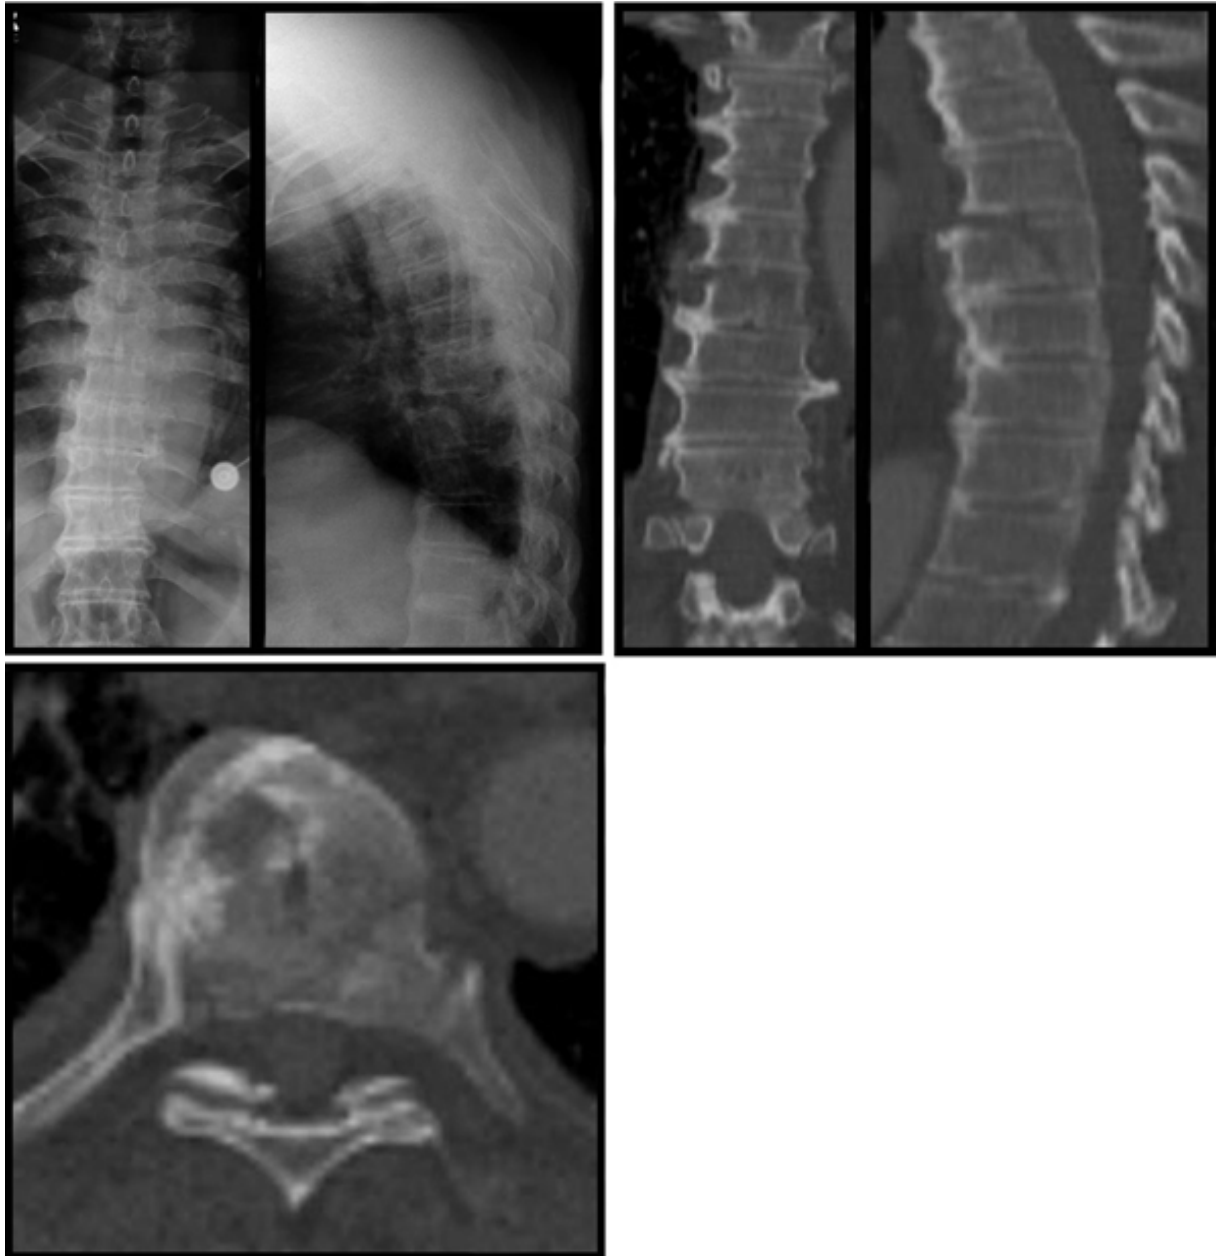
Images of a 74-year old man who was involved in a crash accident. On conventional radiographs merely a sagittal split fracture is identified. Based on this finding alone the fracture would have been graded as stable. CT imaging in this patient clearly proved that often only a combination of transverse slices and secondary reformations allow for proper classification of spine fractures. Thus the sagittal split fracture through the vertebral body is visible only on sagittal reformations whereas the unstable trailing edge was diagnosed on transverse slices only.
